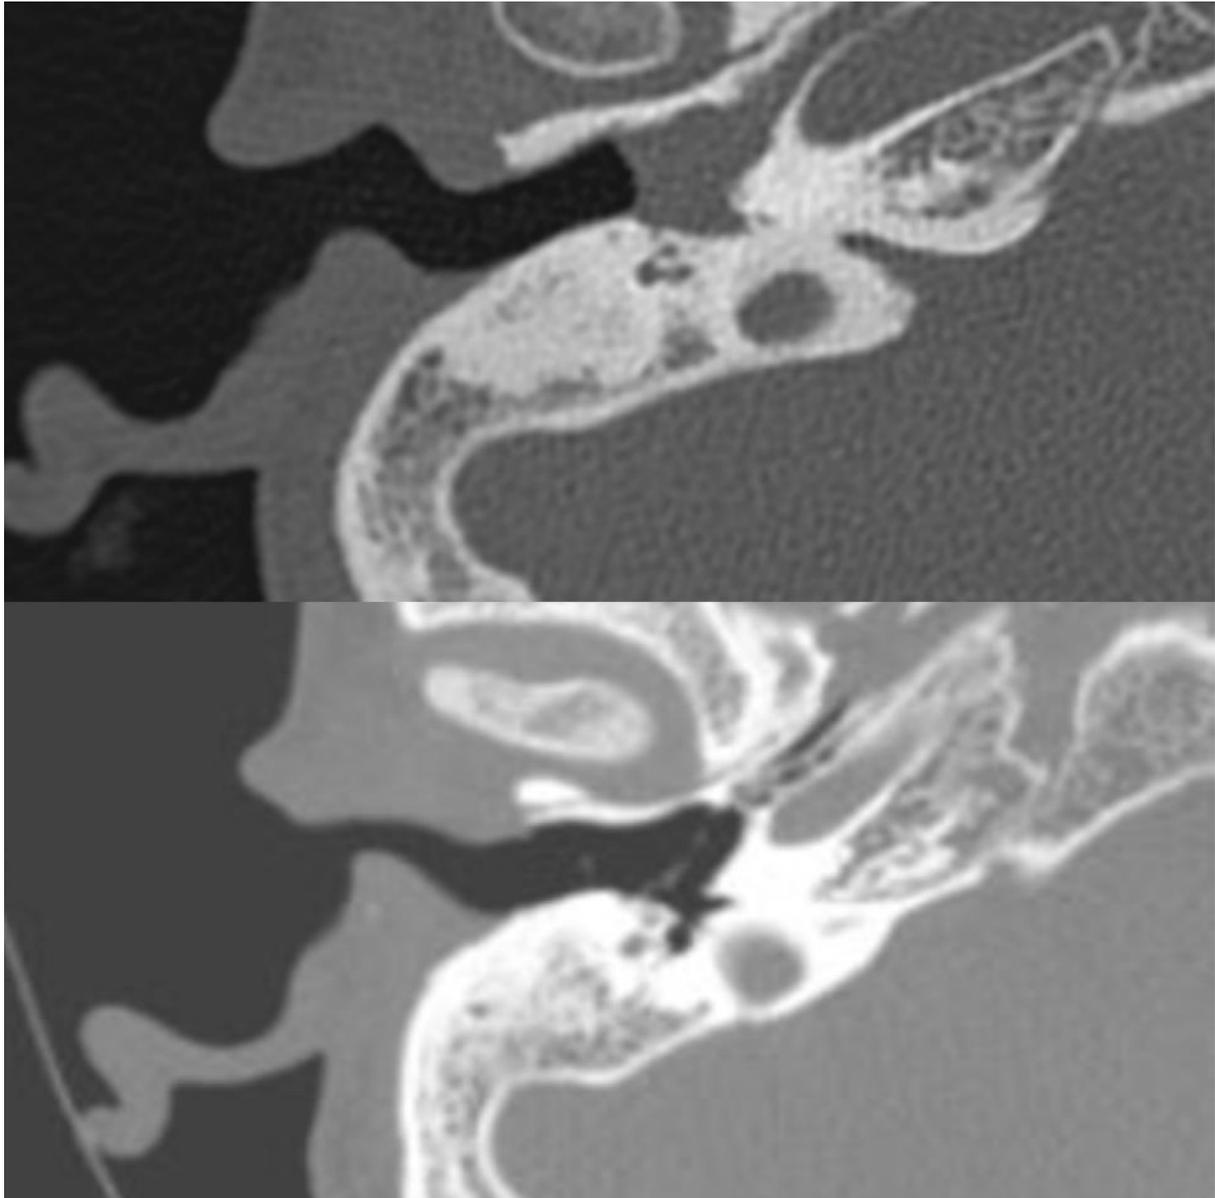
High resolution computed tomography before and after endoscopic ear surgery
